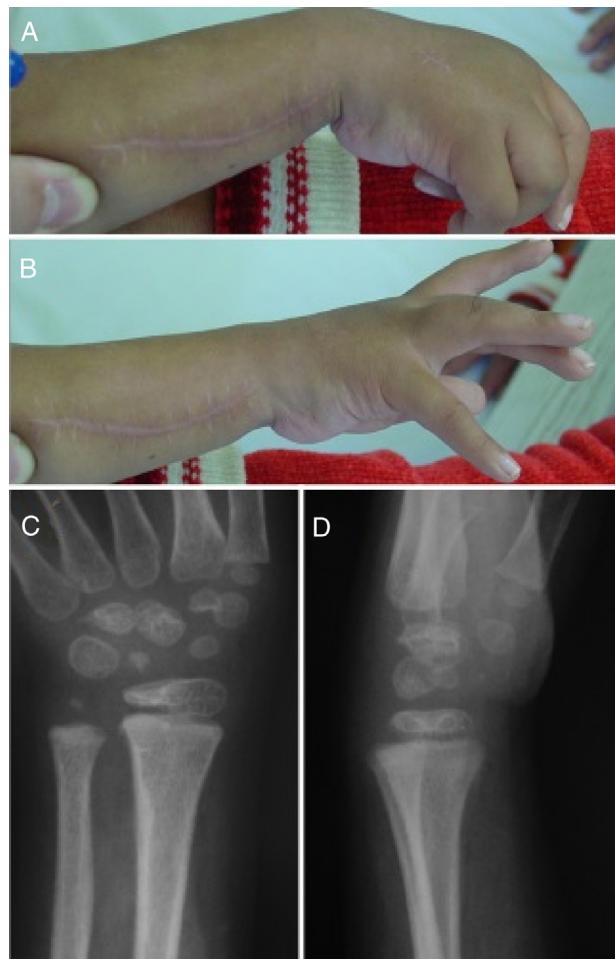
Results at 120 months of follow-up. Good mobility of the fingers and 30° of active mobility of the wrist (A and B). Radiographs show good alignment and coalitions in the mediocarpal joint at the osteotomy site (C and D).
